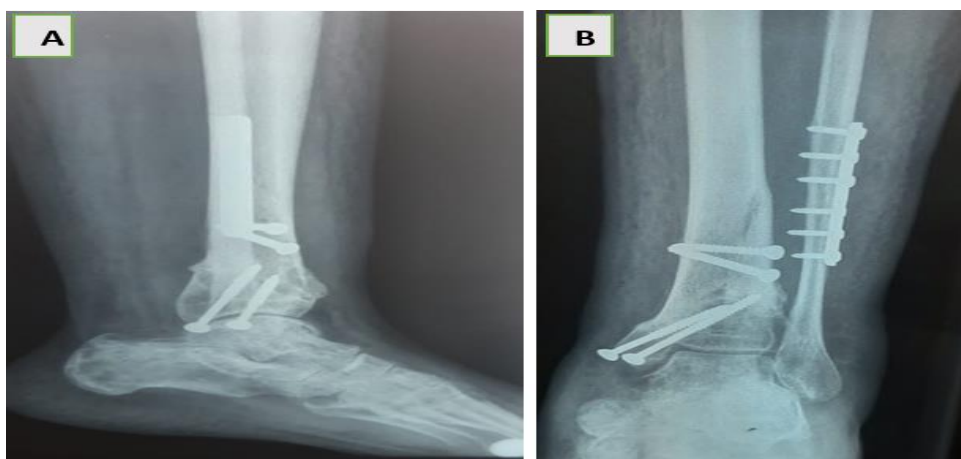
Control radiograph after 3 months of surgery in front (A) and side (B) views showing fracture consolidation
